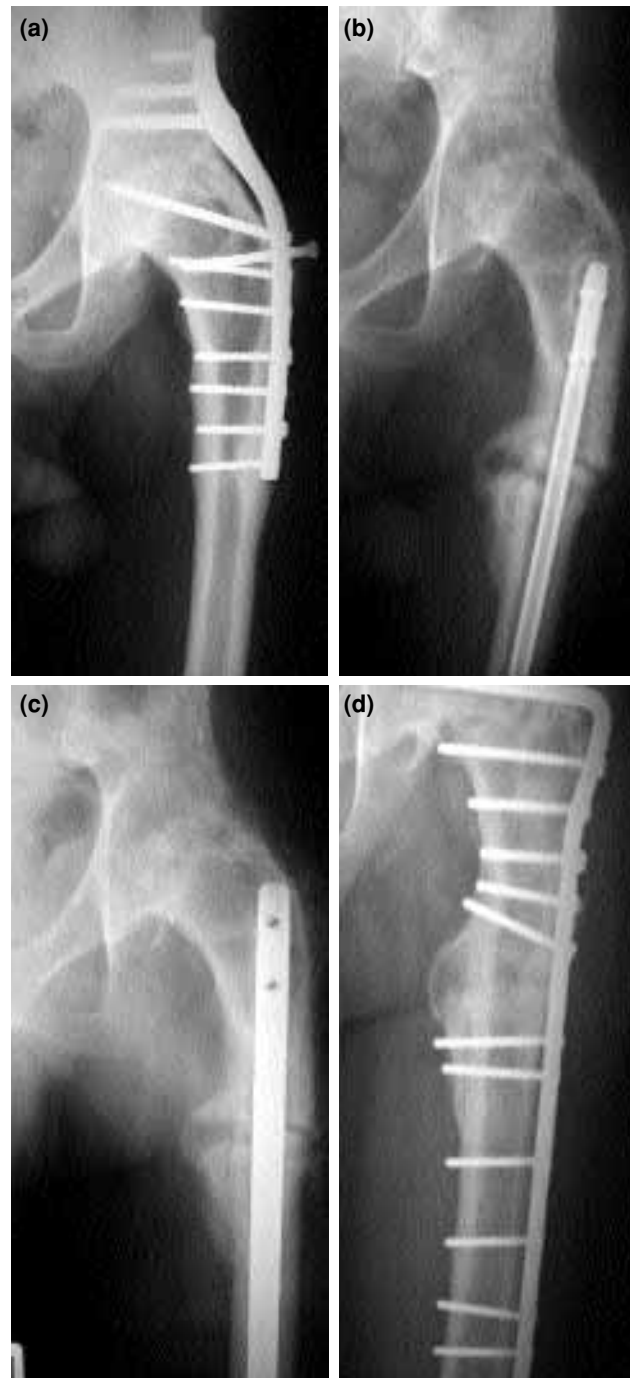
(a) Radiograph of case 2 showing a primary hip fusion with cobra plate. (b) Radiograph on presentation showing nonunion of a subtrochanteric femur fracture. (c) Radiograph following exchange of nailing and bone grafting of fracture site. (d) Radiograph after second operation showing removal of intramedullary nail and placement of a fixed angled device.
